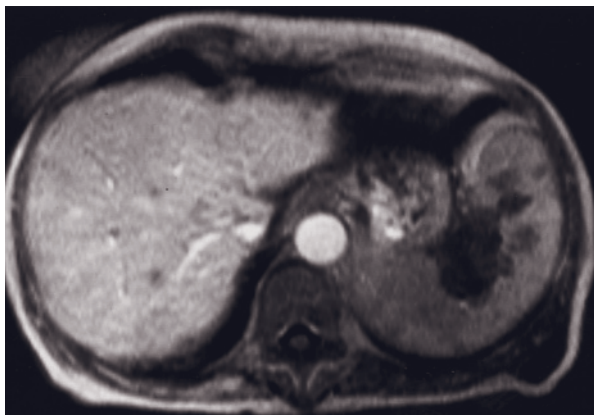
(Continued) SGE (b) images in a second patient with Hodgkin lymphoma receiving chemotherapy. There are multiple small hypointense lesions on T1 (e)- and T2 (f)-weighted images, which shows peripheral or diffuse enhancement after contrast administration (g, h) reflecting the different stages of the fibrotic process. These lesions remained stable in appearance in follow-up MRI exams (not shown).
